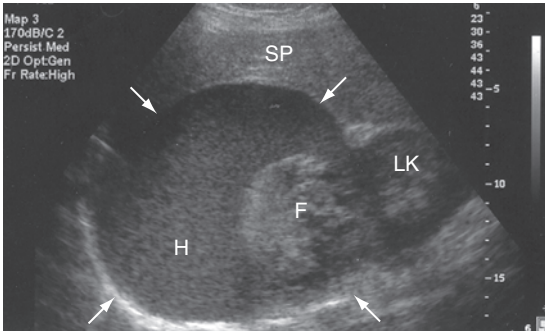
Adrenal myelolipoma mimicking a renal mass. A sagittal sonogram demonstrates a large heterogeneous adrenal mass (arrows) superior to the left kidney (LK). It contains a central echogenic area (F) representing fat and a fluid area (H) with low-level echoes representing hemorrhage. Large adrenal masses are often indistinguishable from renal masses. SP—spleen.
